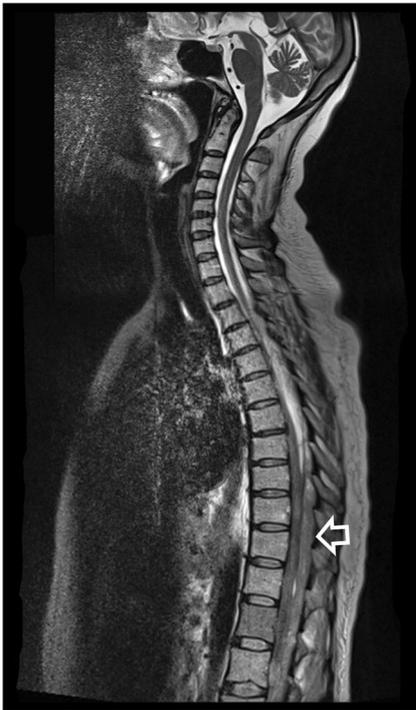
Sagittal T2-weighted MRI of the cervical and thoracic spine showing process inside the spinal canal causing compression and ventral dislocation of the medulla
